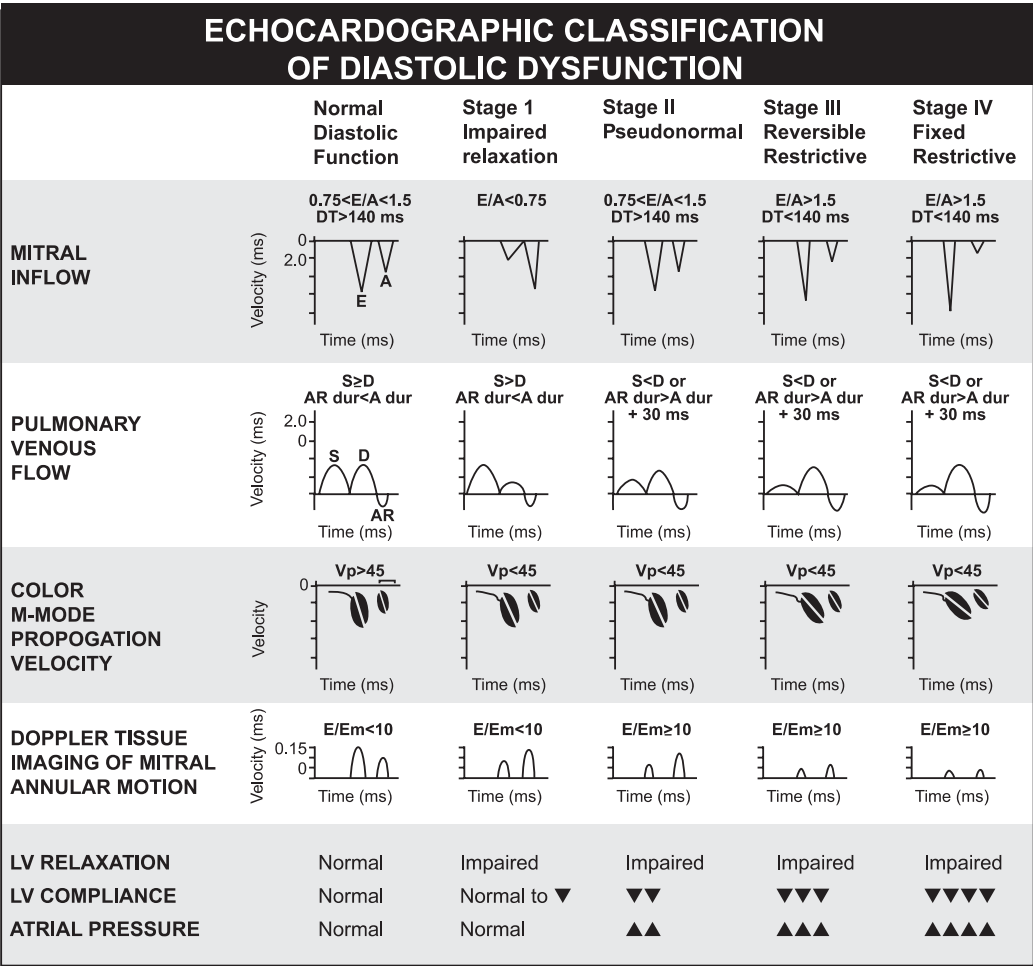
Echocardiographic classification of diastolic dysfunction adapted for transesophageal echocardiography (A, peak late diastolic transmitral flow velocity; A dur, duration of mitral inflow A-wave; AR dur, peak pulmonary venous atrial reversal flow velocity duration; D, peak diastolic pulmonary venous flow velocity; DT, deceleration time; E, peak early diastolic transmitral flow velocity; Em, peak early diastolic myocardial velocity; LV, left ventricular; S, peak systolic pulmonary venous flow velocity; V_p, flow propagation velocity). Adapted for TEE. [With permission of Khouri et al. (42).]
